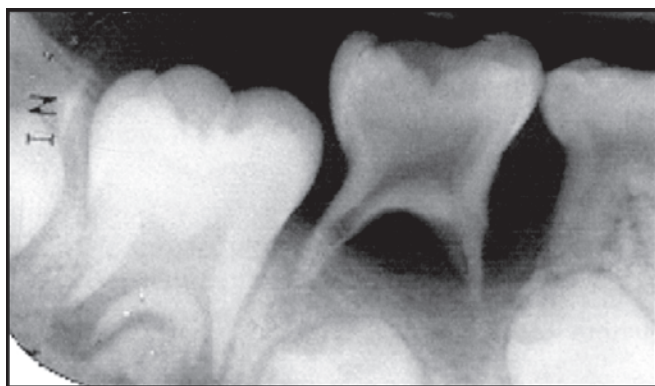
Pre-extraction radiograph furcation involvement and bone resorption of 85
